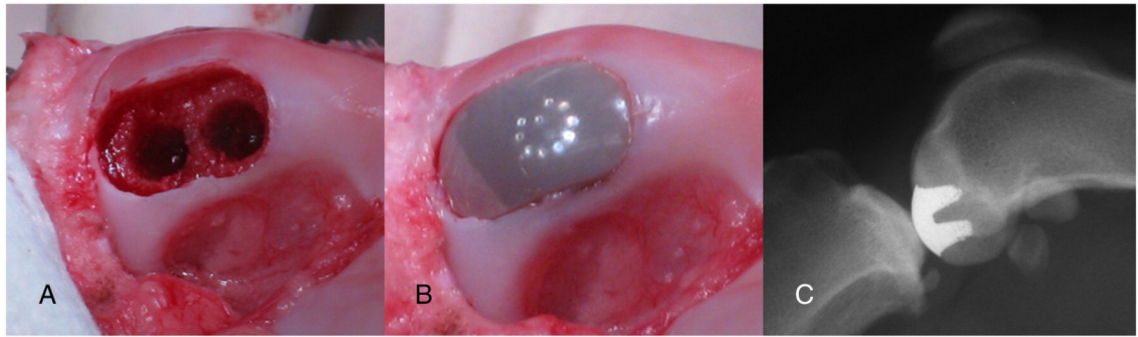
Surgical procedure and postoperative radiograph. (A) Insertion site. (B) Inserted implant. (C) Representative lateral knee radiograph.
